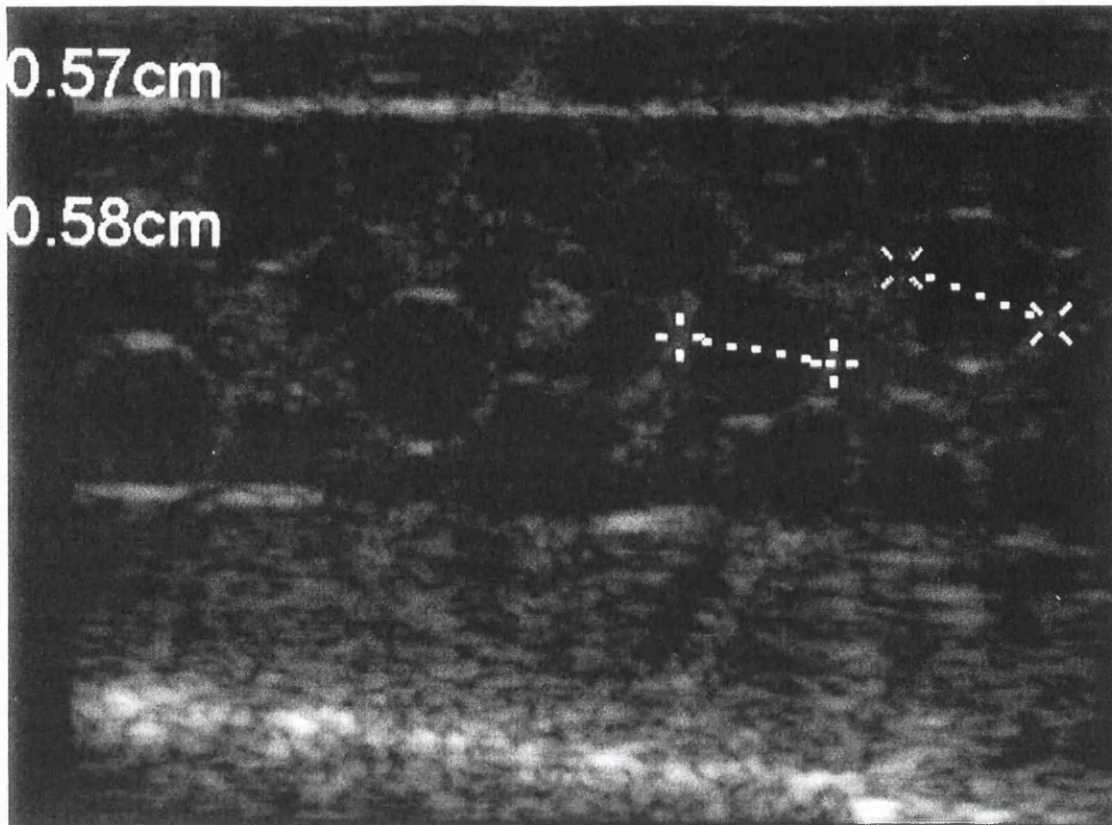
An ultrasound image of eggs within an Atlantic salmon from the November 2003 sample showing the measurements taken.
